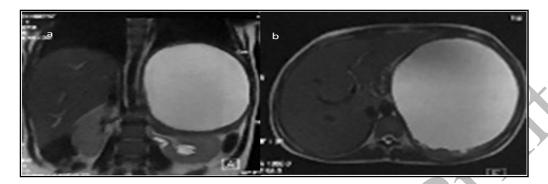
Coronal (a) and axial (b) T2w MRI images show presence of large cystic lesion in spleen.
